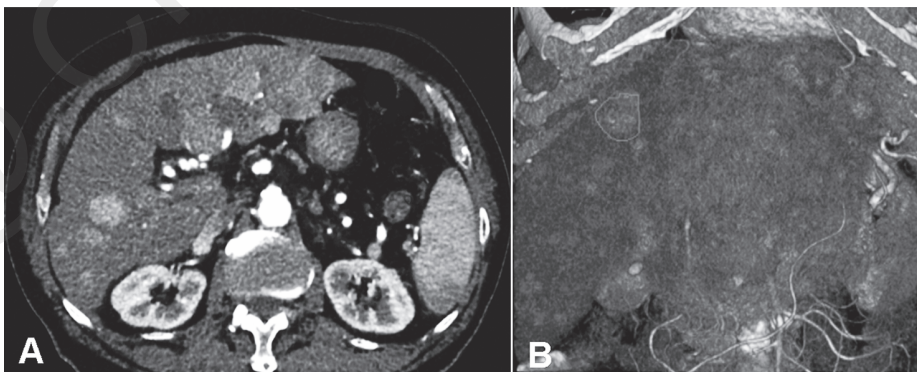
Multicentric HCC. A. CT transverse scan of target lesion in the arterial phase. B. Same lesion assessed by 3D analysis software.
